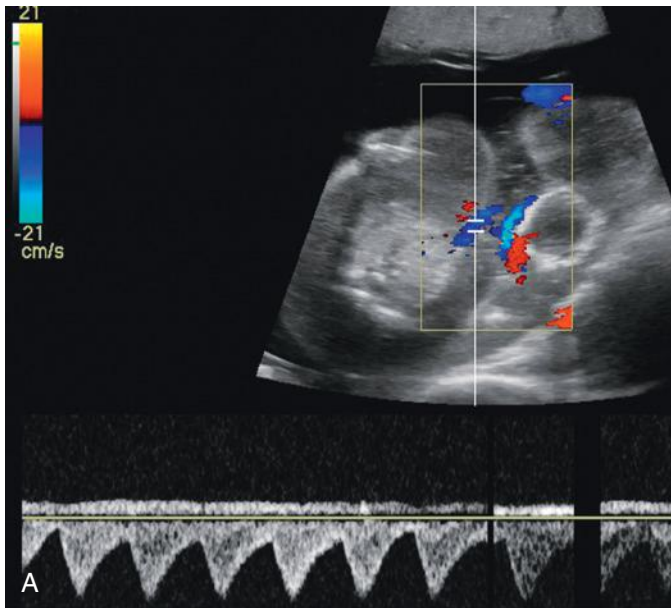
Twin reversed arterial perfusion (TRAP). A, Color and spectral duplex Doppler interrogation demonstrates reversed arterial flow directed into the acardiac fetus at the level of the umbilical cord insertion at the anterior abdominal wall. B, Electronic calipers placed to measure a large anencephalic acardiac parietal twin. Diffuse intersegmentary edema and large cystic hygromas are noted.
